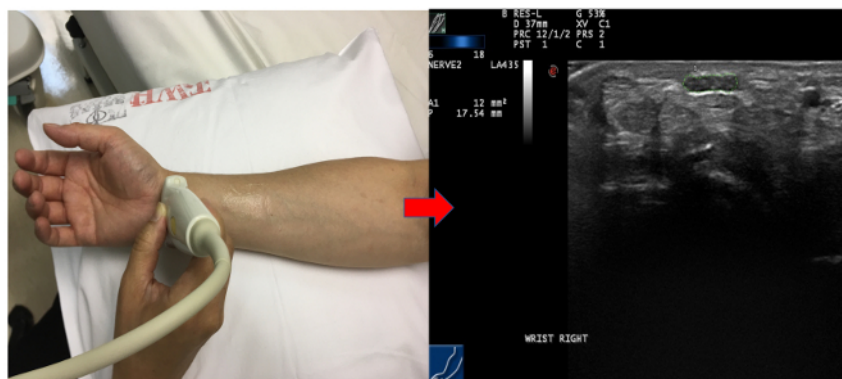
Measurement of the inlet of the carpal tunnel and its ultrasound imaging. [Please click here to view a larger version of this figure.](#)
